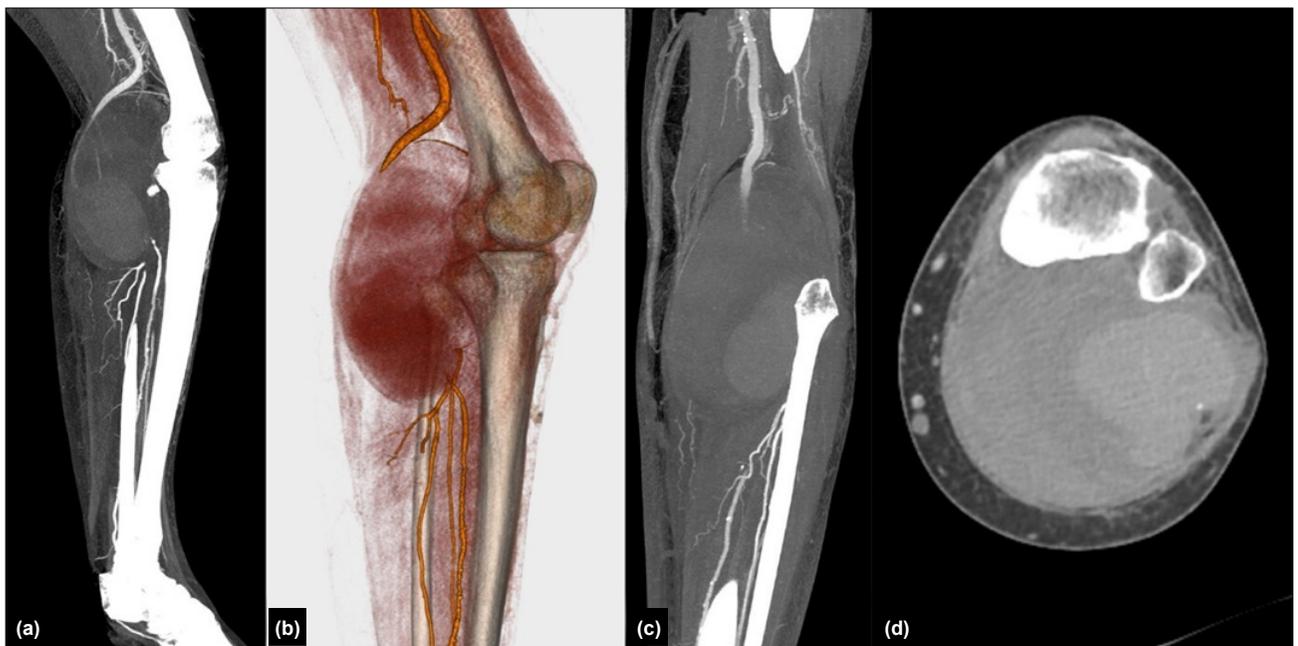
Computed tomography (CT) angiography of the patient. (a,c) Sagittal and coronal plane CT angiography images of the left lower extremity, respectively. (b) Three-dimensional CT angiography image of the left lower extremity. (d) Transverse plane CT angiography image of the left lower extremity. This image shows that the aneurysm is very close to rupturing by eroding the skin.
